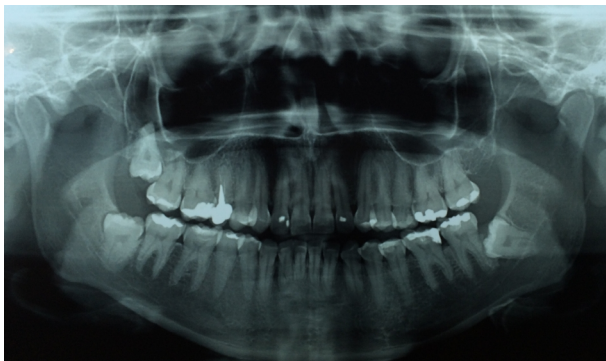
Pre-extraction panoramic radiograph: Note the lower right third molar included in a vertical position.
